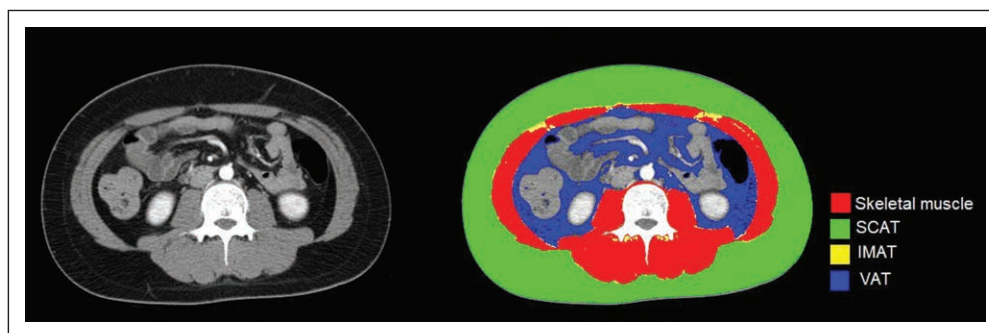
Example of a CT scan at the level of the third lumbar vertebrae. IMAT = intramuscular adipose tissue, SCAT = subcutaneous adipose tissue, VAT = visceral adipose tissue.
